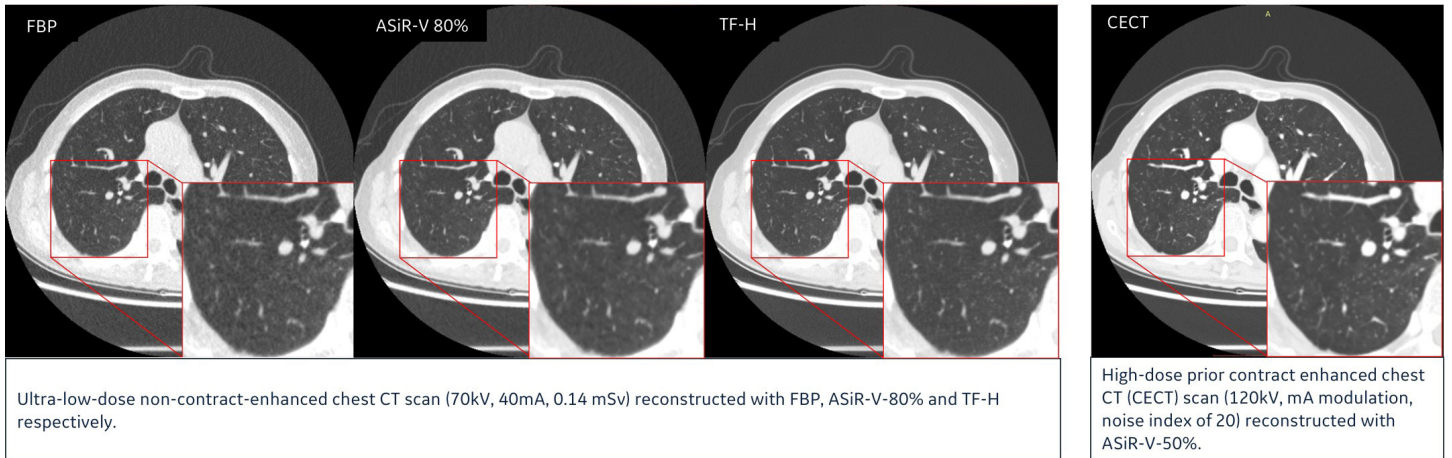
Comparison of CT image reconstruction algorithms in ultra-low-dose (0.14 mSv) chest CT. A 72-year-old male patient with BMI 19 kg/m² and a clinical history of lung cancer surgery in the right middle lobe, received prior high dose CECT (reconstructed with ASiR-V-50%) and ultra-low dose (0.14 mSv) non-contrast chest CT (reconstructed with FBP, ASiR-V-80%, TF-H). The red outlined area shows the details of the magnified images of lung parenchyma. The ultra-low dose TF-H image shows clearer lung parenchyma and details, comparable to the high dose CECT image. Courtesy of Dr. Xueqian Xie, the Department of Radiology, Shanghai General Hospital, Shanghai, China.
